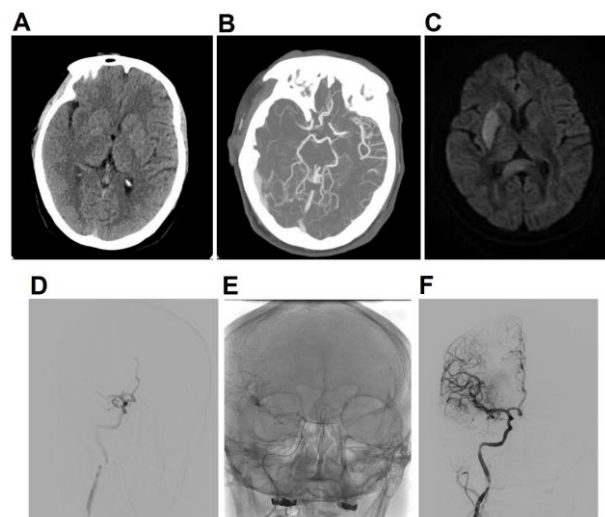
Imaging of the 2nd stroke. A. CT pre-procedure; B. CTA showed thrombus in both MCA and ACA; C. MRI 24h post thrombectomy; D. Angiography confirmed both MCA & ACA occlusion; E. Solombra technique in MCA and stent-retriever in ACA; F. TIC1 3 archived post thrombectomy
